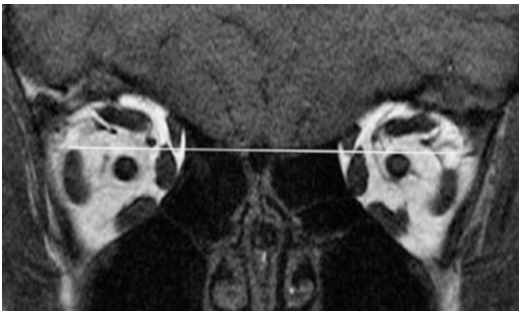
Coronal orbital MRI of a patient with pulley heterotopia. The left lateral rectus muscle (LR) is infra-placed with respect to the right LR. In some patients this can cause a divergence insufficiency pattern esotropia, and in others it may cause a hypotropia of the affected eye (from Kushner [53], with permission)
